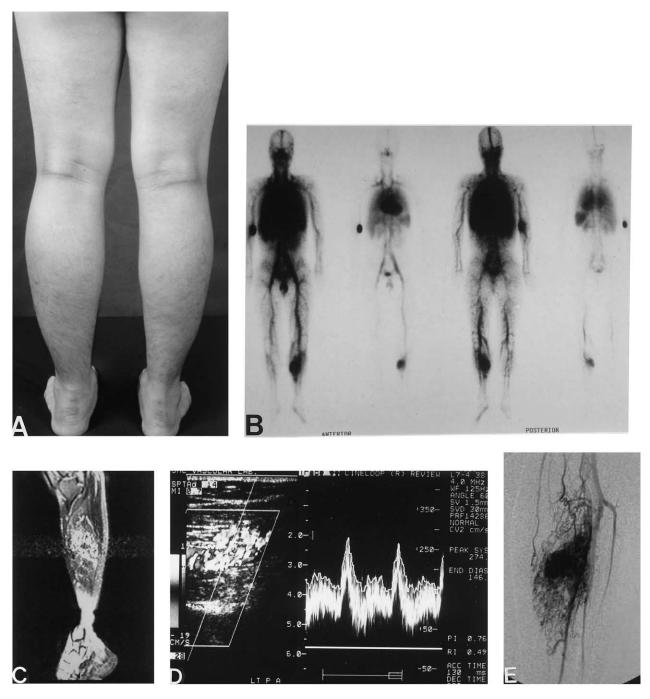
"Staged" embolo/sclerotherapy with absolute ethanol and coil, to a recurred AVM. A, Clinical appearance of left calf swelling with increasing pain, after unsuccessful embolo/sclerotherapy done elsewhere. B, WBBPS finding of the lesion within the left calf with abnormal blood pool (pretreatment). C, MRI finding to confirm the diffuse infiltrating type of extratruncular form of AVM within the calf muscles (pretreatment). D, Duplex scan finding of hemodynamically high-flow status along the feeding artery at the popliteal artery level (pretreatment). E, Arteriographic finding of AVM lesion to confirm the extratruncular form with the nidus (pretreatment).
